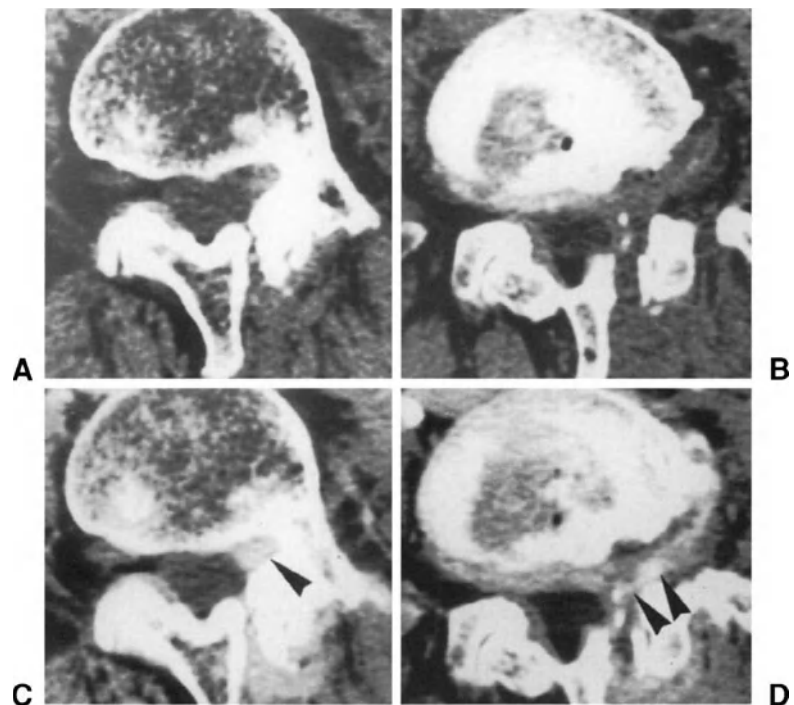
Postsurgical fibrosis in a patient operated on for a left L4-L5 intraforaminal herniation. (A) and (B) Axial CT scans in basal conditions. (C) and (D) After injection of contrast medium: increased density of the tissue situated in the site of previous surgery (arrowheads). The tissue surrounds the thecal sac, but does not produce any mass effect on it.
